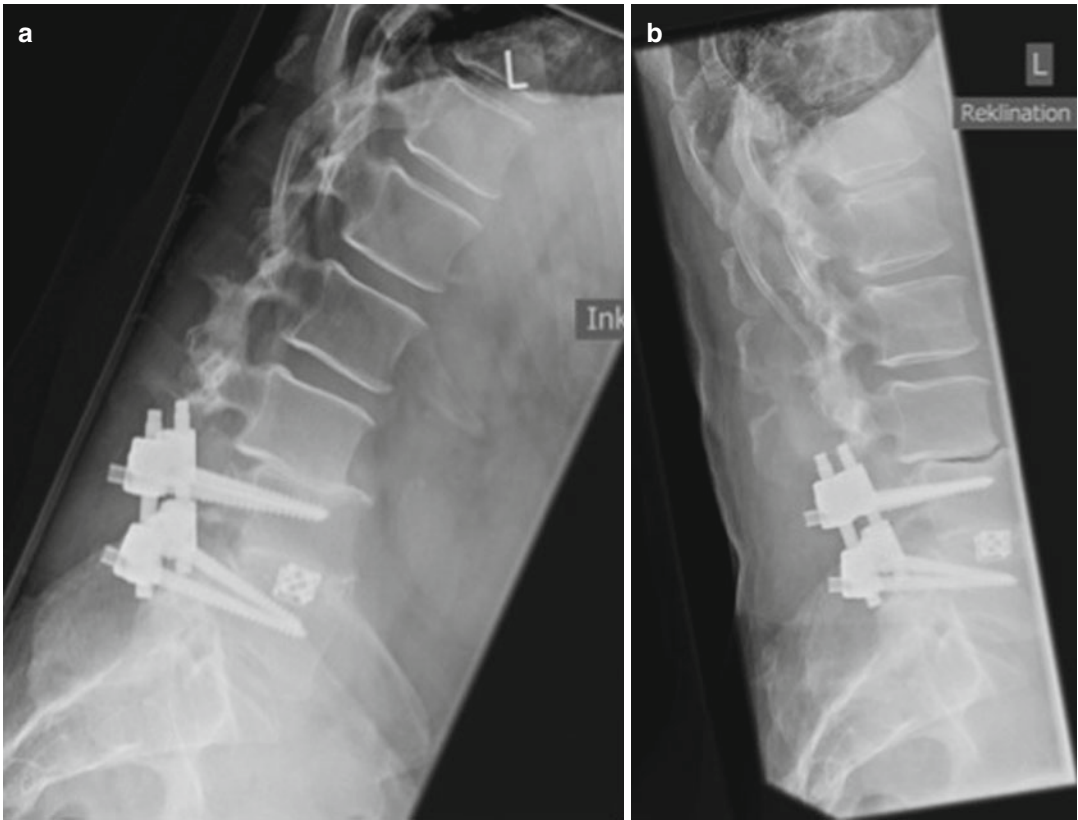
X-Ray in flexion (a) and extension (b) 3 years after the discectomy at the level L3/4
